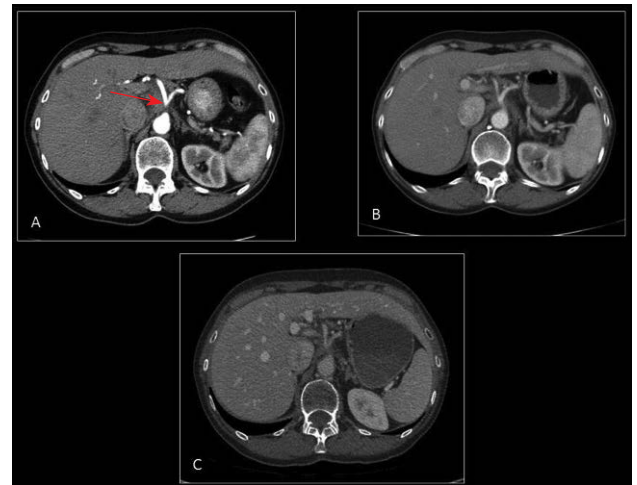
Axial contrast-enhanced CT of the abdomen showing infiltrative pancreatic tumor arising from the pancreatic head/neck and extending superiorly. The tumor encases the celiac axis (red arrow) in the CT scan obtained at diagnosis (A). Decreasing size of the infiltrative tumor with persistent encasement of the celiac axis is seen on the CT scan obtained 3 months (B) and 13 months (C) after completion of chemoradiation.
